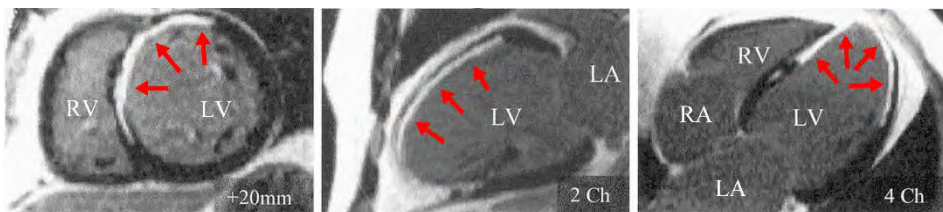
Slices from a cardiac DE-MRI dataset, oriented in the three cardiac planes: short-axis (*left*), long-axis or two-chamber view (*centre*) and four-chamber plane (*right*). *Red arrows* indicate the hyper-enhanced regions in the images resulting from the presence of the gadolinium-based contrast agent within the infarcted myocardium. LV: left ventricle; RV: right ventricle; LA: left atrium; RA: right atrium.
